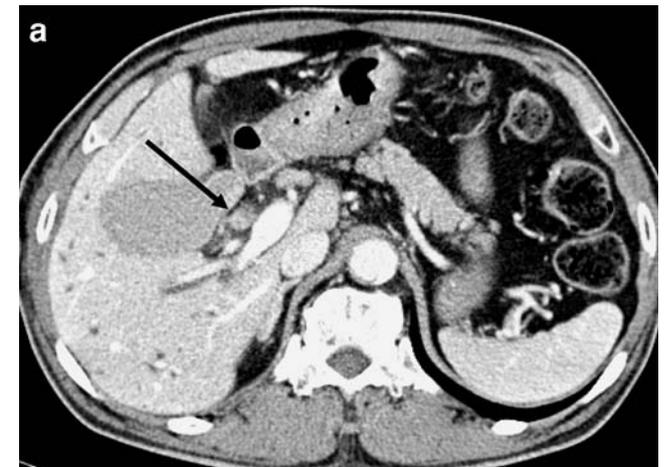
A 68-year-old male with CBD cancer. a Axial CT during the portal venous phase shows a soft tissue tumor in the mid-CBD (*arrow*). Reader 2 interpreted that CBD cancer was resectable with a confidence level 3 (possibly resectable). b Coronal reformation reveals the entire length of the tumor extent (*white arrow*) and its relationship with the vascular structure. The confidence level of reader 2 was elevated to a confidence level 4 (probably resectable) with this reformatted image. The surgical findings revealed that the tumor was resectable
